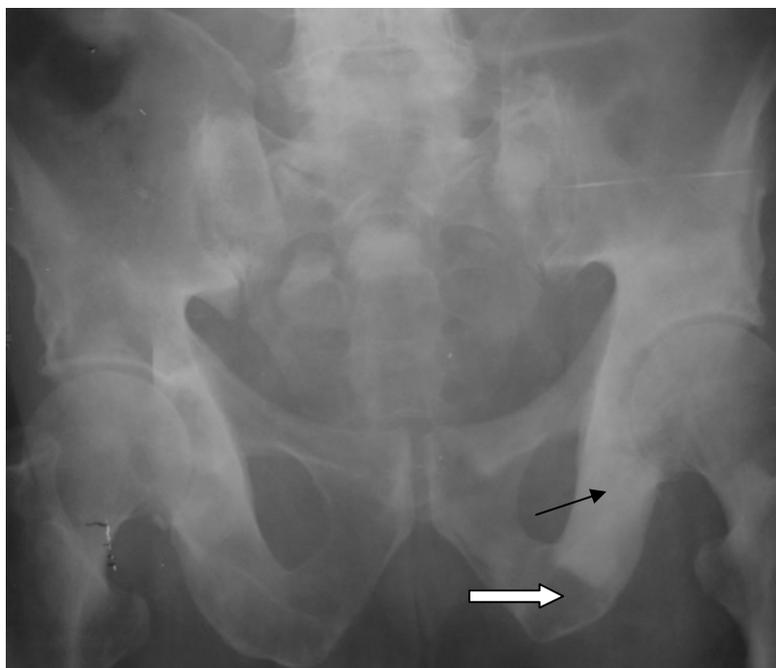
The survey radiograph of the pelvis in a direct projection. Multiple sites of osteosclerosis and destruction in pelvic bones are detected. Separate sites of osteosclerosis and destruction are designated by an arrow and a figured arrow, accordingly. Osteolytic and osteoblastic cancer metastases in the iliac bone is detected.
